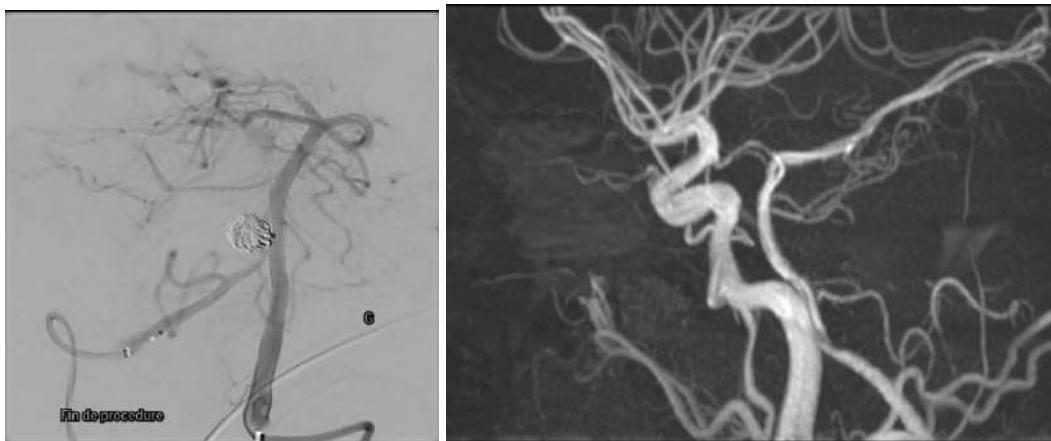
DSA Scan after Stent and Coil Placement Shows No Residual Bulge (A). Magnetic Resonance Image After 3 Months on Tof 3d Pulse Sequence Shows No Residual Bulge (B)
